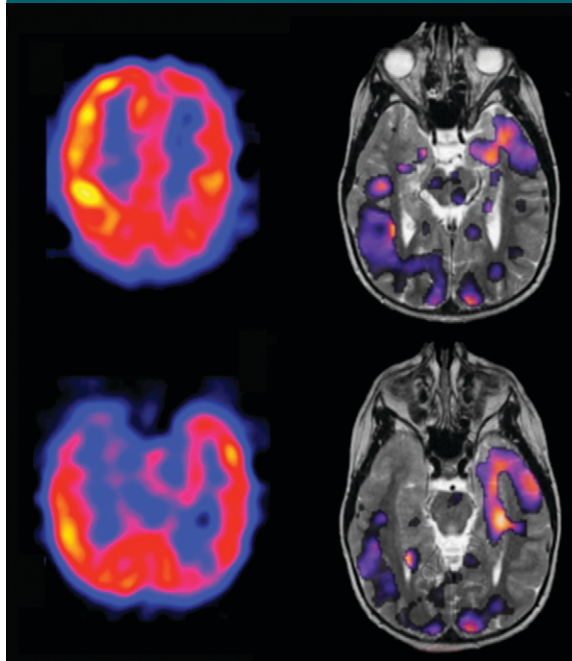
Subtraction ictal SPECT (left) coregistered with MR images (right) are used to localize the region of seizure onset characterized by hyperperfusion for epilepsy surgery planning.
